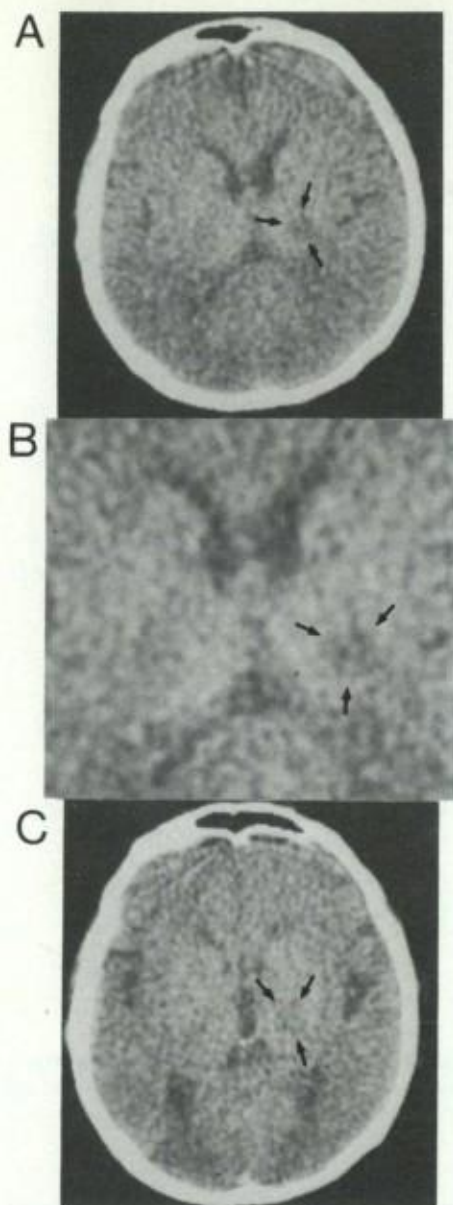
Horizontal CT scan sections showing the left thalamic vascular lesion in patient no. 2. A: small laminar hypodensity in the left posterior thalamus and posterior limb of the internal capsule. B: enlarged view of the lesion site in A. C: CT scan section at a slightly higher level. The small arrows point to the lesion.
